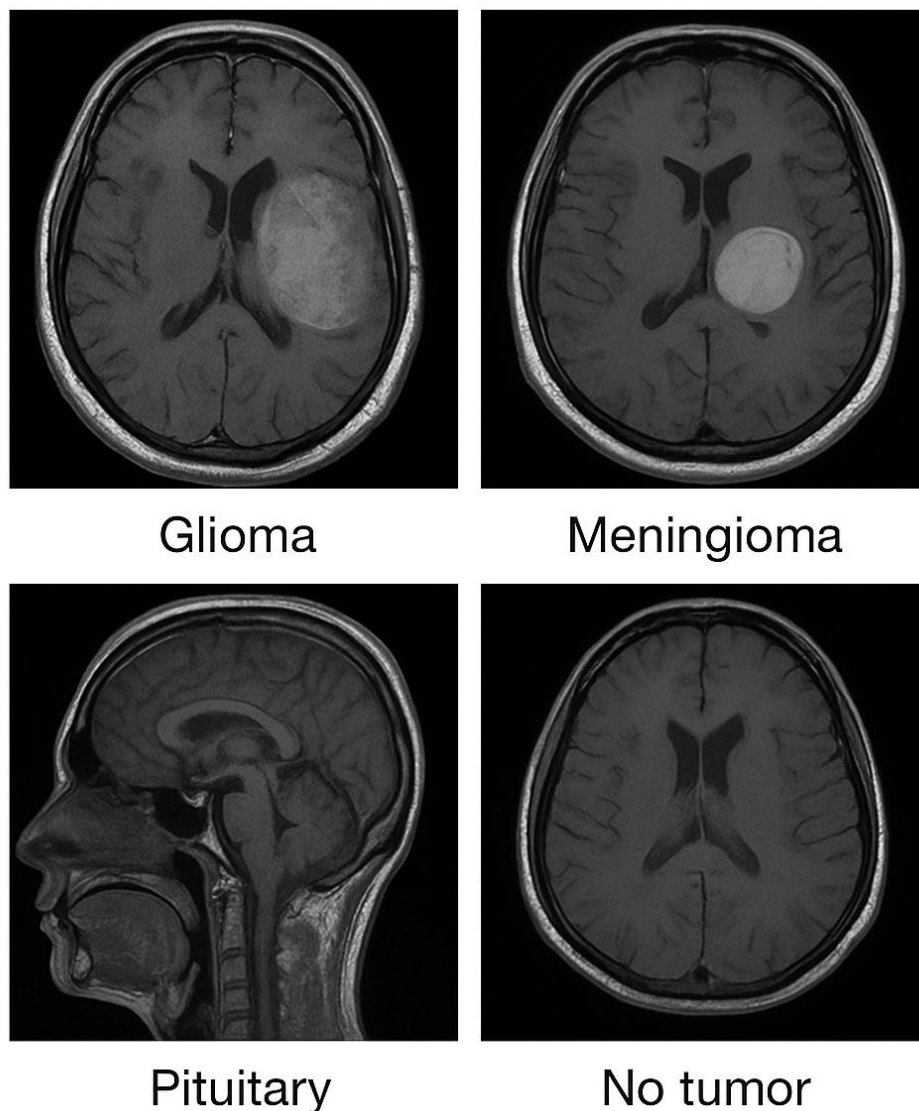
Example MRI images from each tumor class
